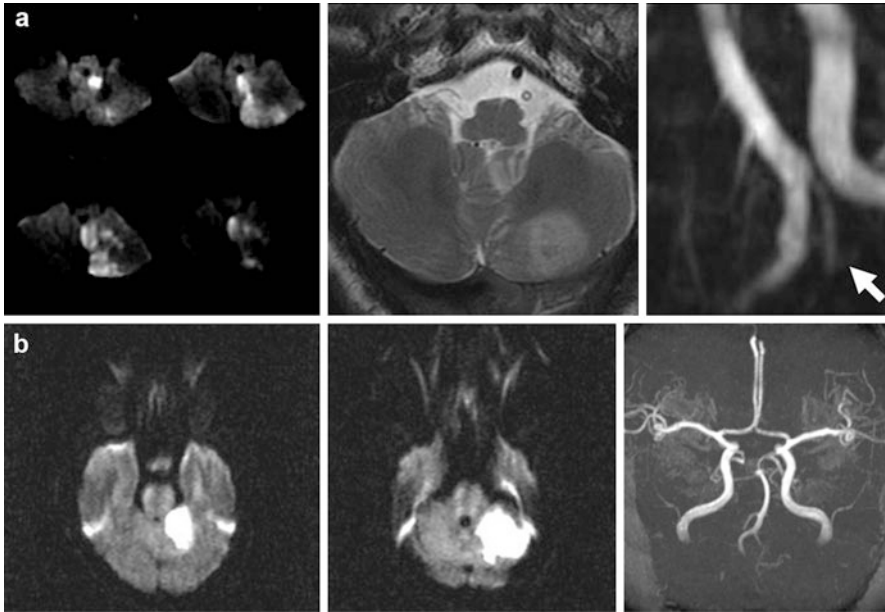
Mechanism of cerebellar stroke. Brain MRI and MRA (a) show left cerebellar infarction in the PICA territory (*left panel*) and diffuse stenosis of the left vertebral artery (*right panel*). The stroke mechanism is thought to be artery-to-artery embolization from the left vertebral artery proximal to the orifice of the left posterior inferior cerebellar artery. *Lower images (b)* show left SCA infarction. Echocardiography revealed moderate mitral stenosis and dilated left atrium with sludge and suspected thrombi in the left atrium apex. The mechanism of stroke is thought to be cardioembolism to the left SCA
